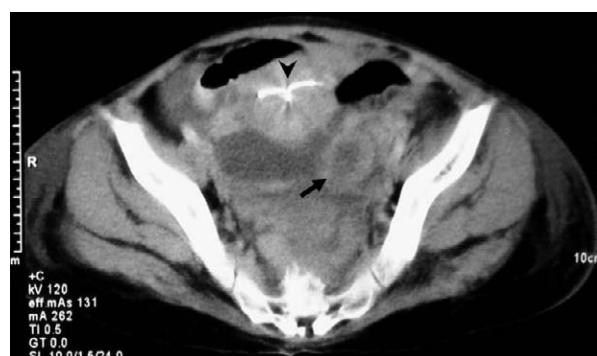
Abdominal computed tomography reveals formation of abscess (arrow) and the intrauterine device inside the uterus (arrowhead).
